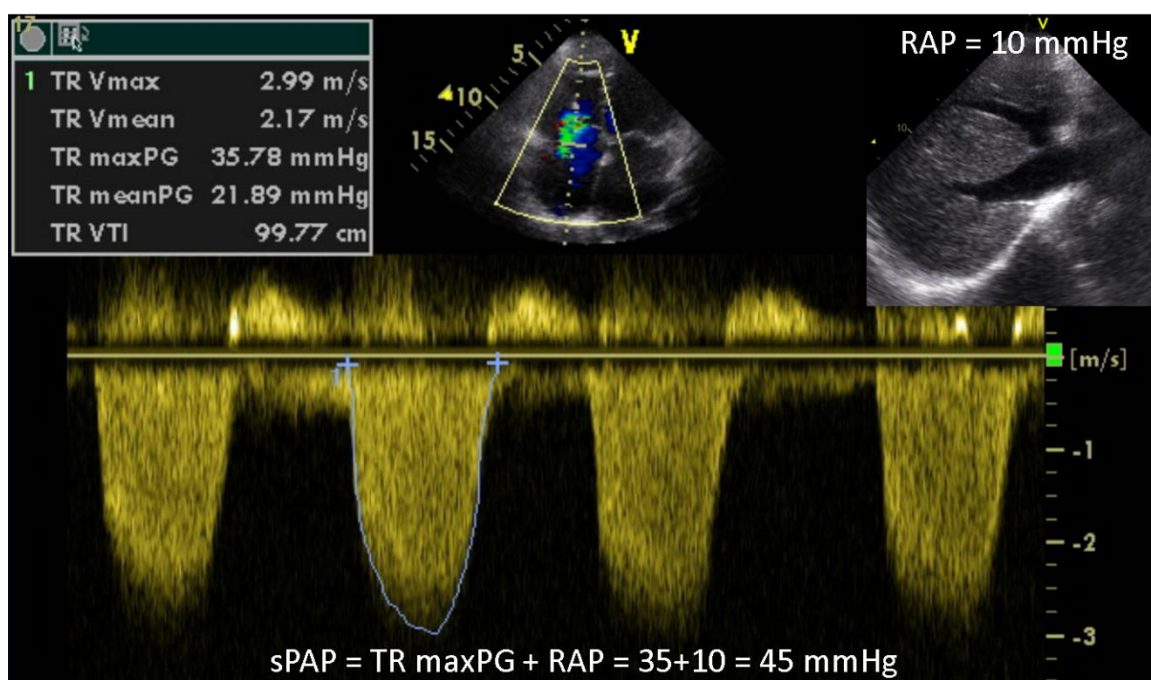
Echocardiographic measurement of systolic pulmonary artery pressure (sPAP), which is calculated as $sPAP = 4 (TRV_{max})^2 + RAP$, where TRVmax indicates the peak TR jet velocity and RAP right atrial pressure.
